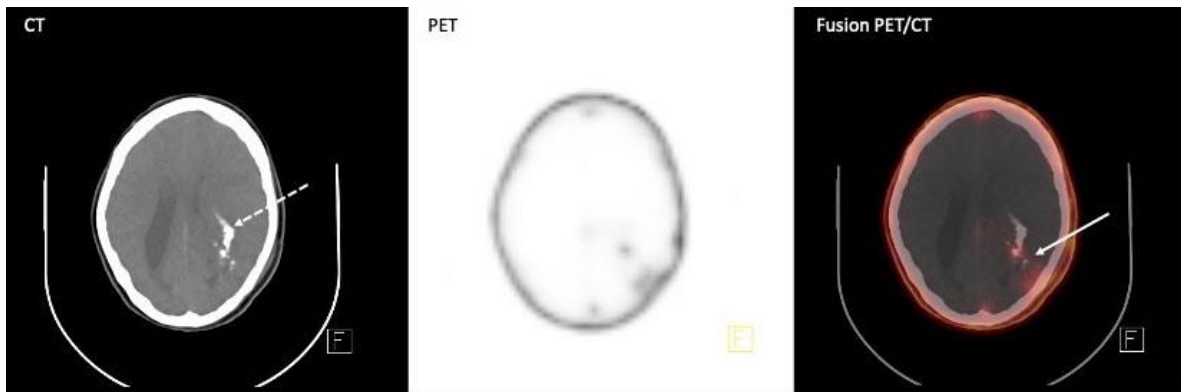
Brain [⁶⁸Ga] Ga-Pentixafor PET/CT. mild CXCR4 avidity (SUV_{max} : 1.68) in the left occipito-parietal lobe (solid arrow) with evidence of adjacent calcification (dotted arrow)
